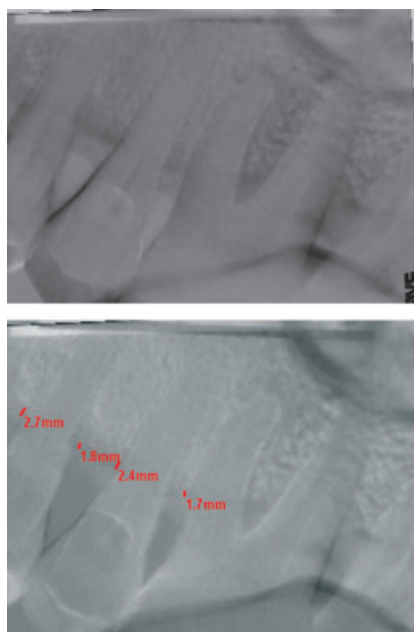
Digital subtraction radiography image resulting from the subtraction of the sixth month image from the baseline one and linear measurements of the black areas (bone resorption) of this digital subtraction radiography image.
